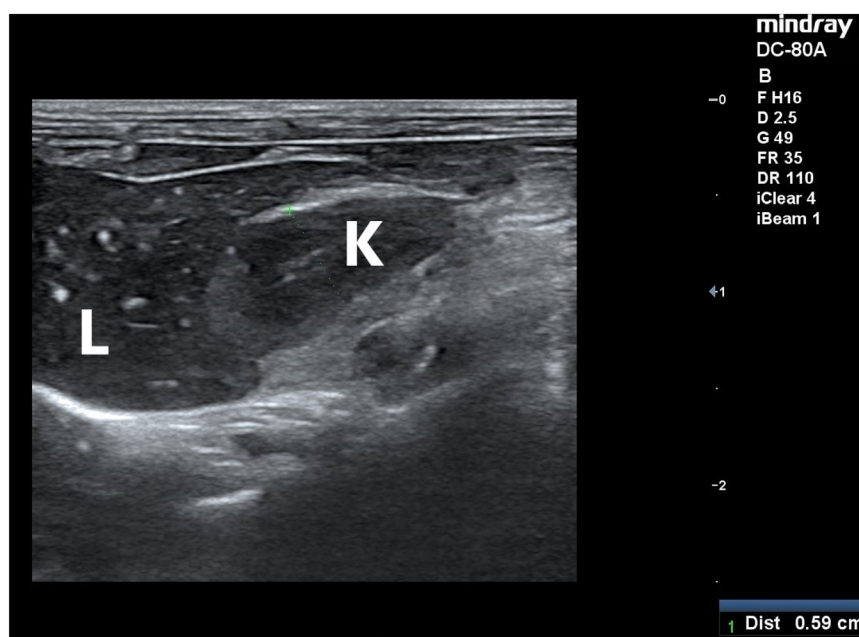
Ultrasound showed an enlarged liver (L), while the liver parenchyma had numerous small, calcified lesions. The right kidney (K) was also visible, located next to the liver lobe
